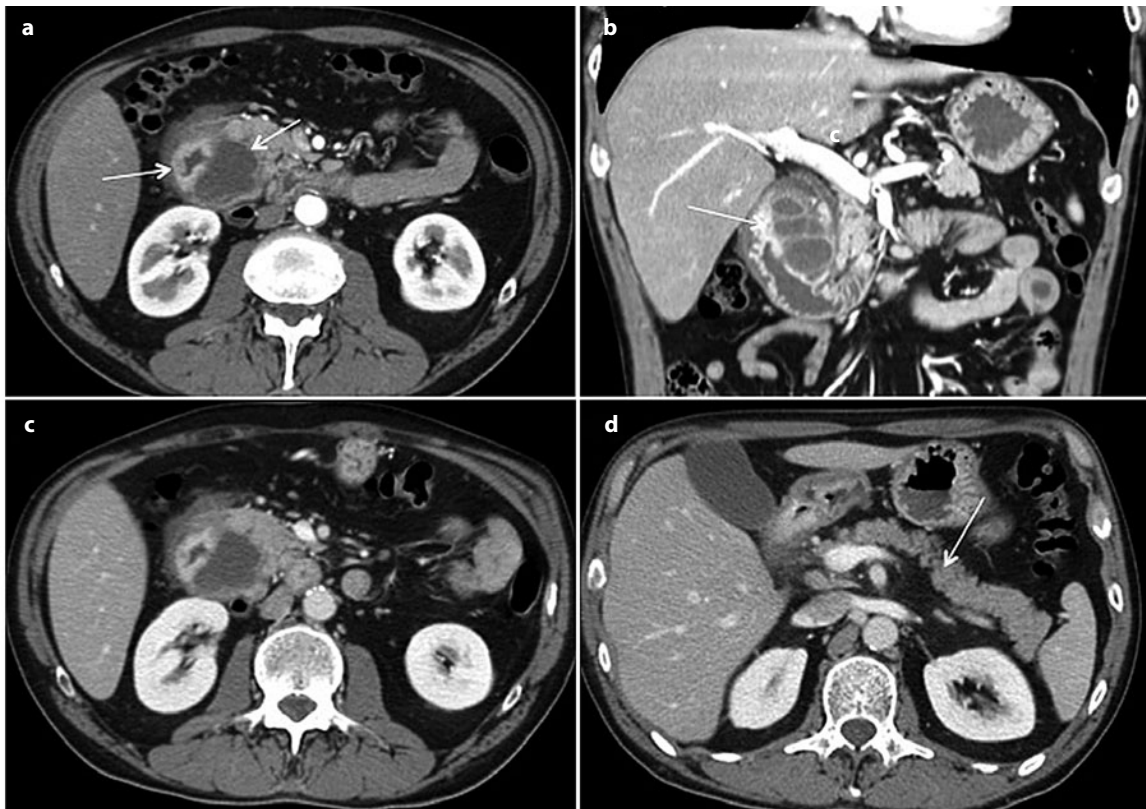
a-d. Groove pancreatitis in a 44-year-old man. Multidetector computed tomography (MDCT) examination shows a multilocular collection (*arrows*) with well-defined margins, characteristically located between the descending tract of the duodenum and the pancreatic head; duodenal walls are clearly enhancing both on a arterial and b venous phases. No dilation of the main pancreatic duct (b) or the intrahepatic biliary tree (d) is appreciable. The head of the pancreas (c) is compressed; the other portions of the gland (d) show regular morphology and enhancement (*arrow*)
